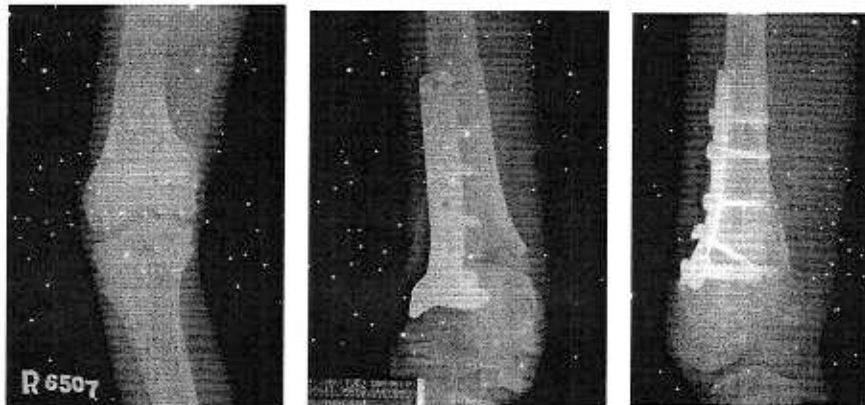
X-rays of an 8-year-old boy suffering from simple bone cyst who underwent curettage and had the cavities packed with freeze-dried bone allografts. Left: preoperative X-ray; middle: immediate postoperative X-ray; right: 2-year postoperative X-ray.
